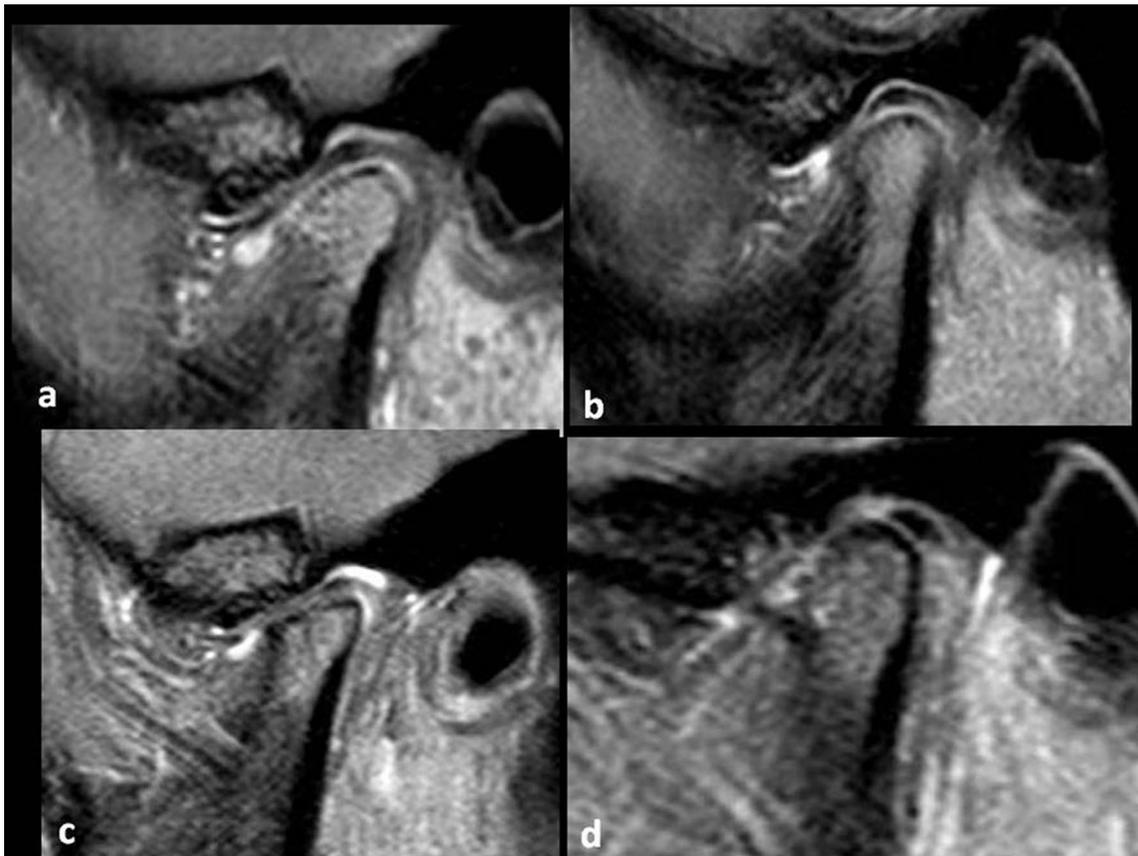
Patient 12: sagittal post contrast fat saturated T1-weighted MR images (c, d) demonstrate worsening of arthritis including flattening of bilateral mandible condyles with irregular articular margins compared to previous MRI (a, b) in 1 year
